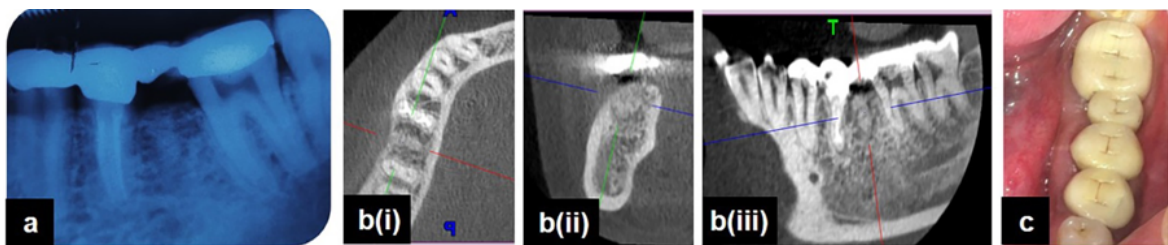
9-months follow-up: (a): Periapical radiograph; (b): CBCT views; i): Axial, ii) Coronal; iii): Sagittal, (c): Clinical view
